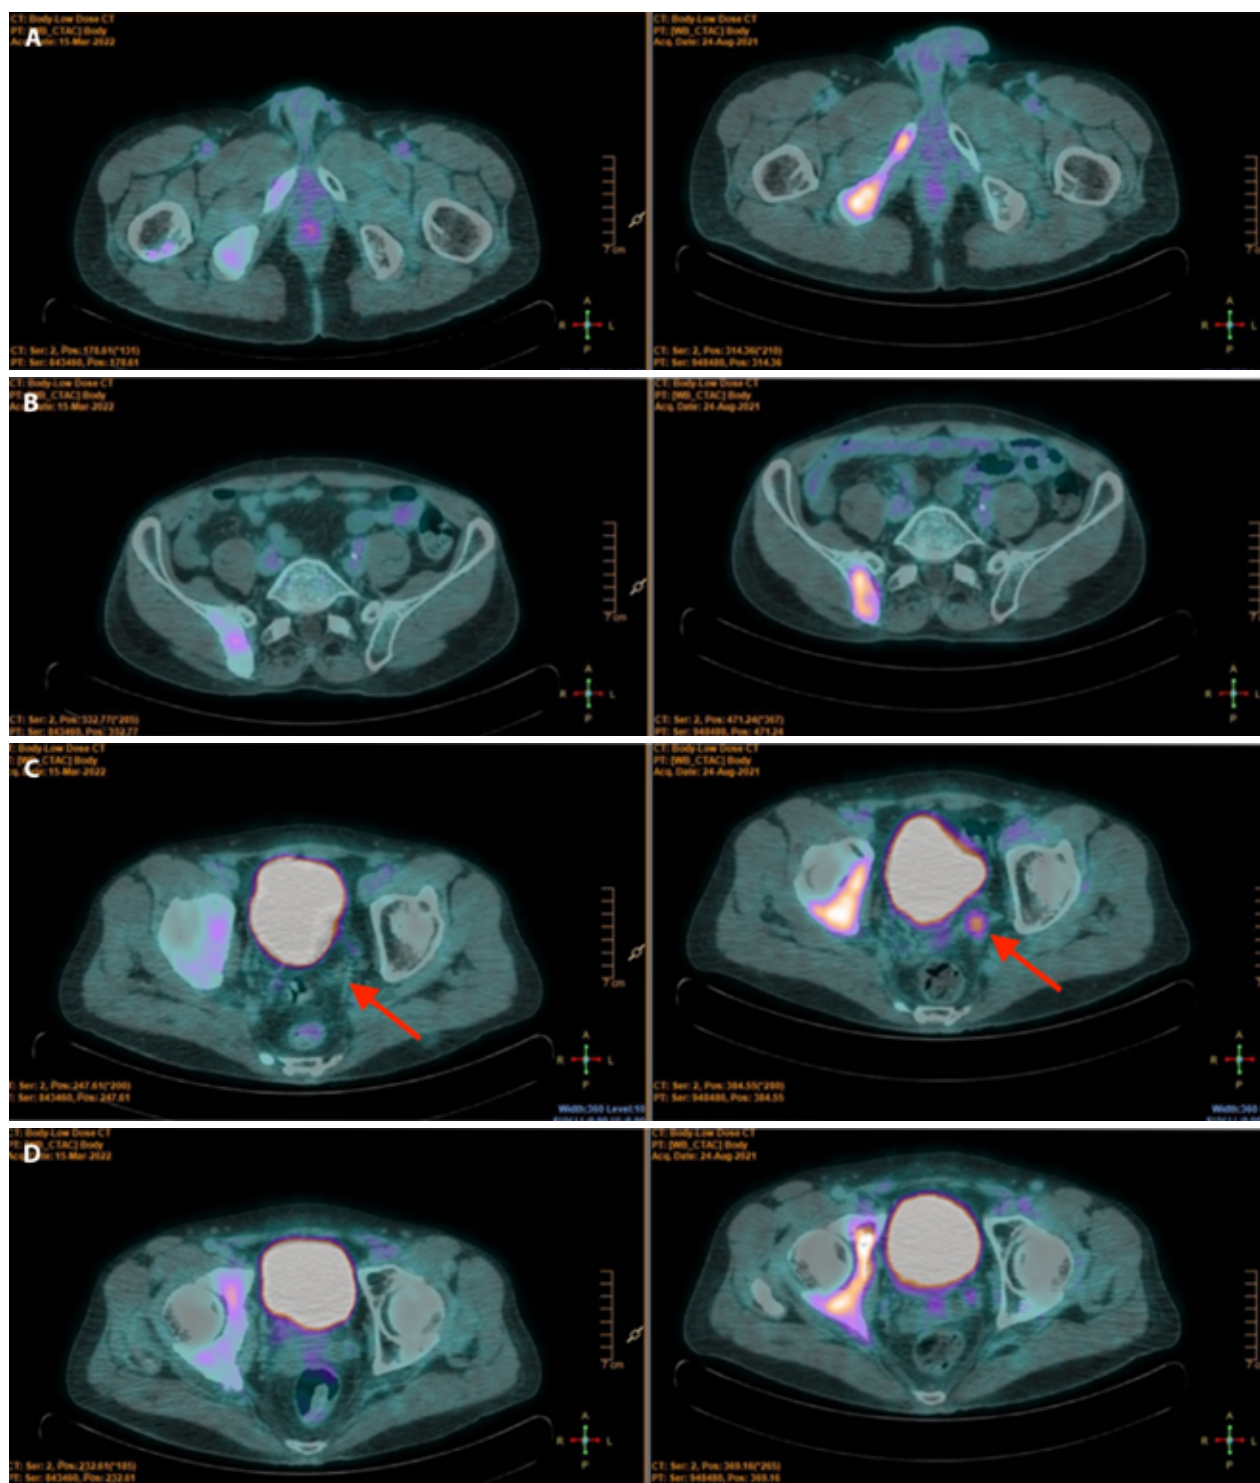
Comparative 18-F-FDG-PET/CT images of metastatic lesions before enfortumab vedotin start (on the left) and after six months of treatment (on the right). In August 2021, hypermetabolic activity was reported in right ischium pubic segment (A), in right iliac bone (B), in right acetabulum (C-D) and in the known pelvic pathological tissue on the left of the bladder (C). In March 2022, no metabolic activity of pelvic pathological tissue (C) and a notable reduction of 18-FDG uptake in bone lesions (on the right A-B-C-D) have been reported.
